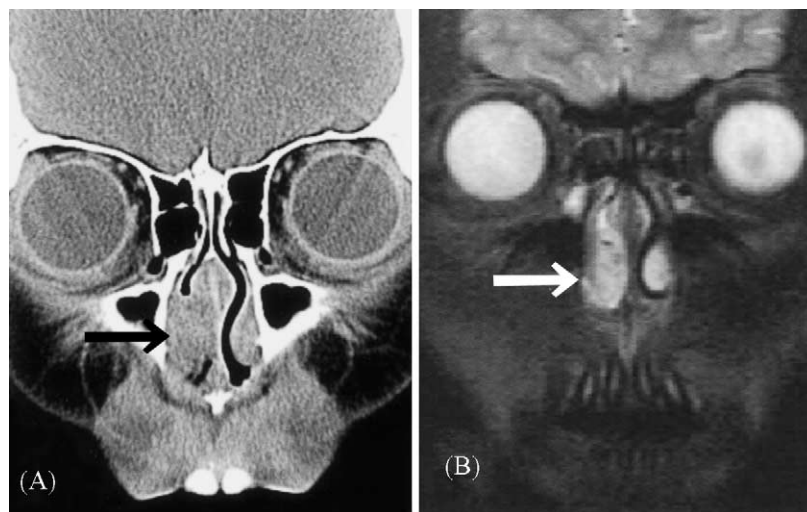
(A) Coronal CT scan confirmed a mass of the inferior turbinate that filled the right nasal cavity (black arrow) and (B) T2-weighted coronal MRI demonstrated that the mass was hyperintense (white arrow).
